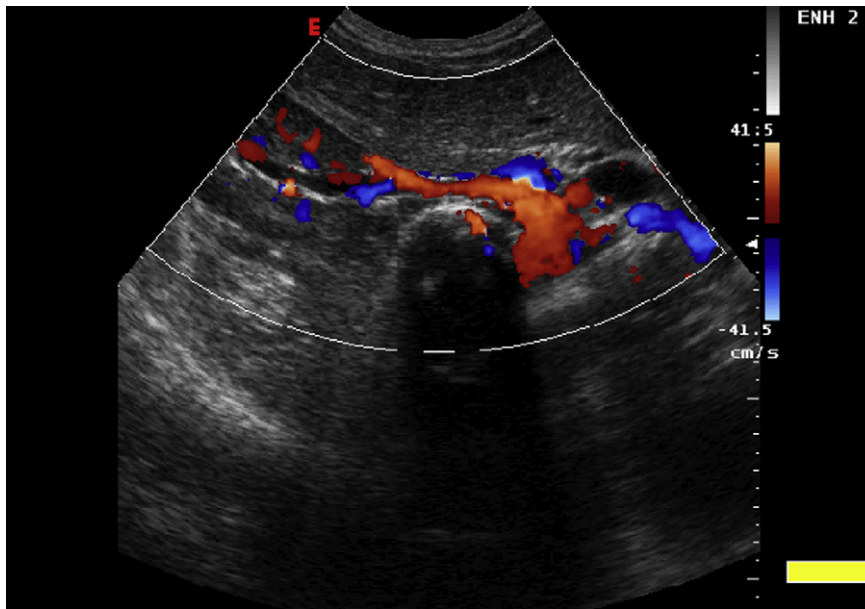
Color-Doppler US image of the right kidney with the renal vessels. Good visualization of the entire renal vascular tree.
